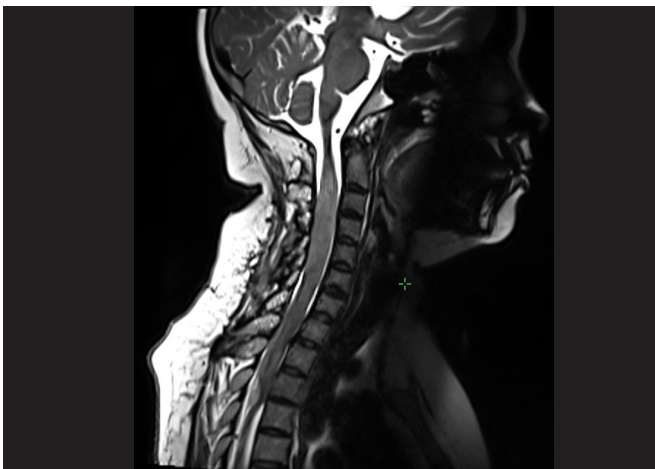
Gadolinium contrast enhanced Post Op MRI showing lesion from the level of clivus till the level of superior endplate of D4 vertebra in Sagittal T2 section
